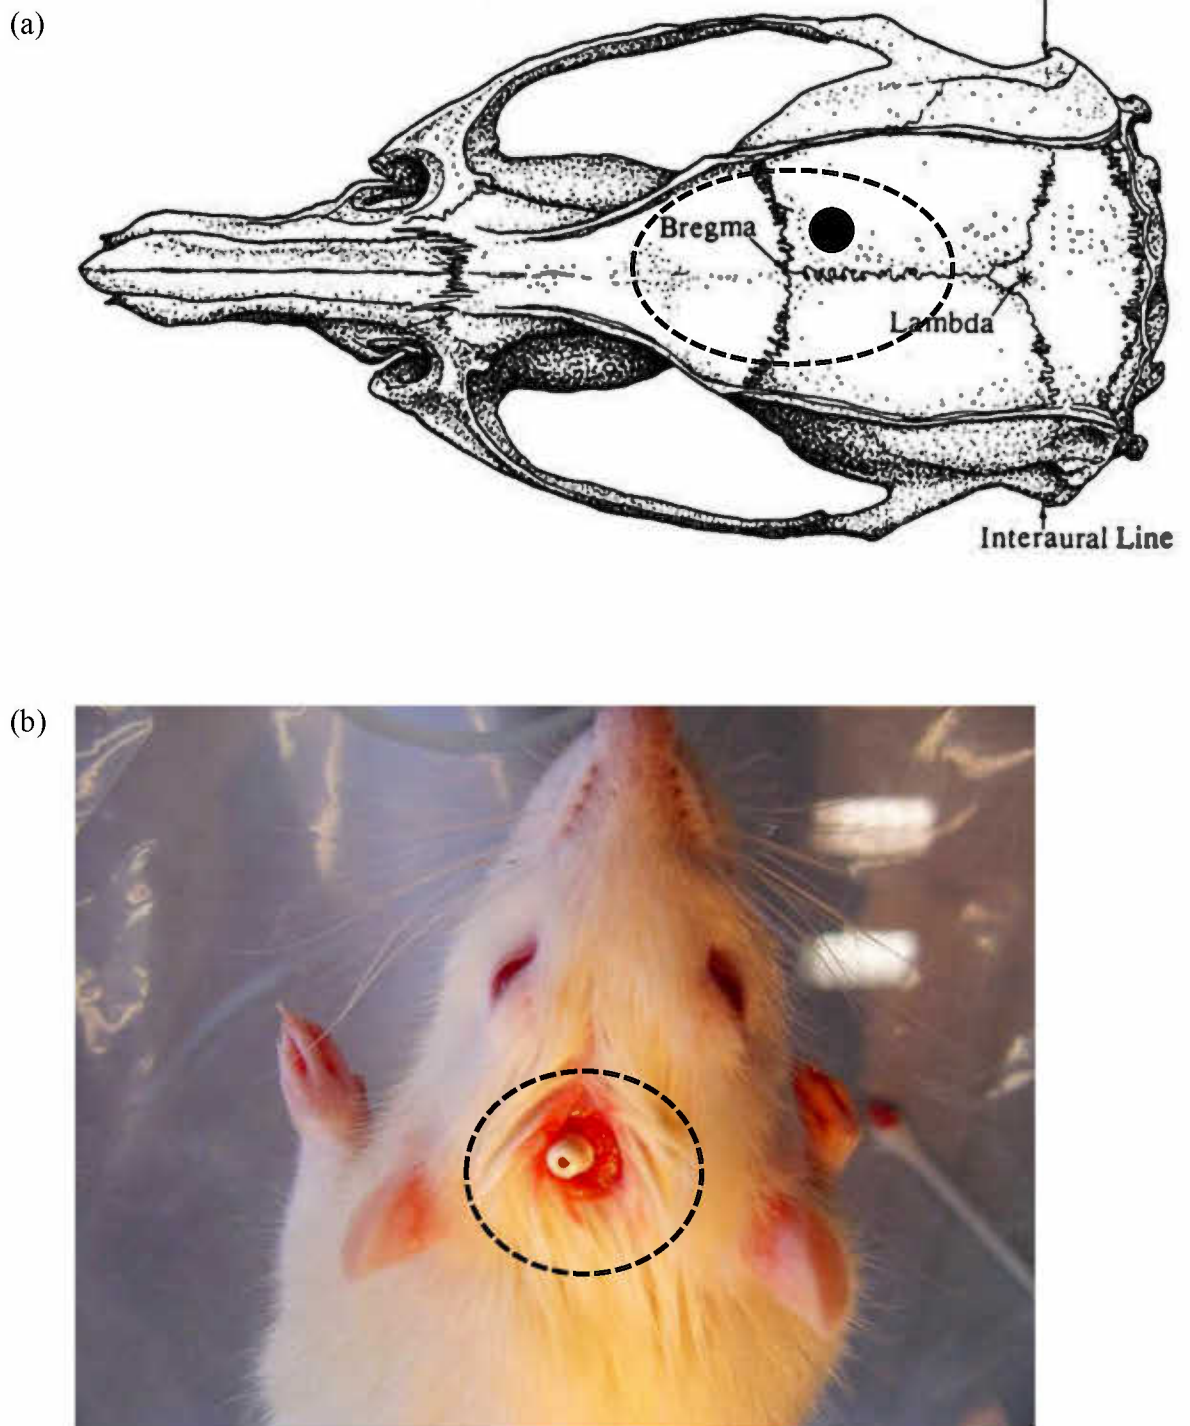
Location of the laser Doppler probe holder (a) as shown by the black spot, on the right hemisphere at 1 mm posterior and 2 mm lateral to bregma (Paxinos and Watson, 2006) (b) Location of the probe holder shown inside the black dotted circle
